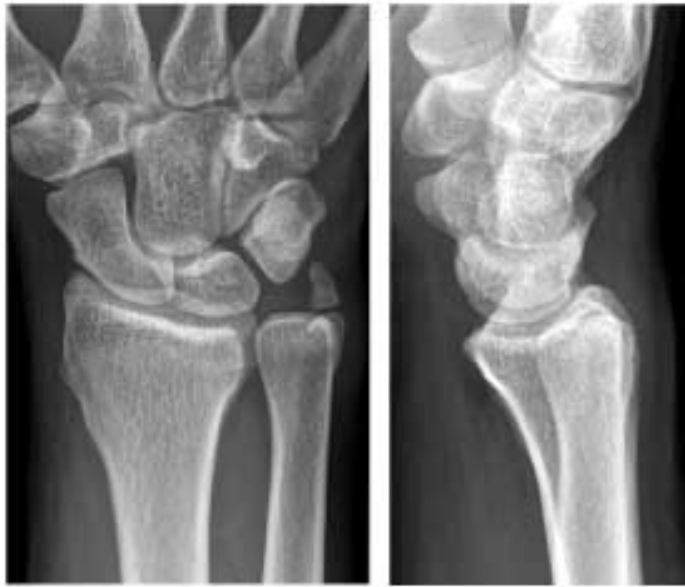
Radiographs in two planes preoperatively
